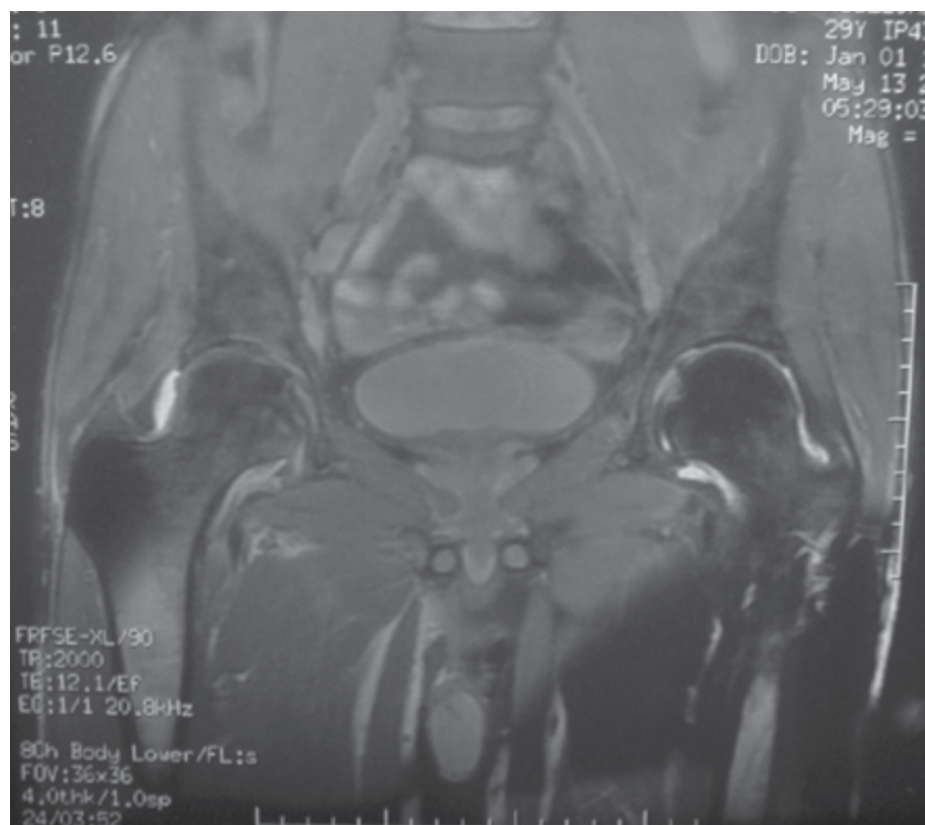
MRI of the pelvis showing bilateral synovitis of the hips
